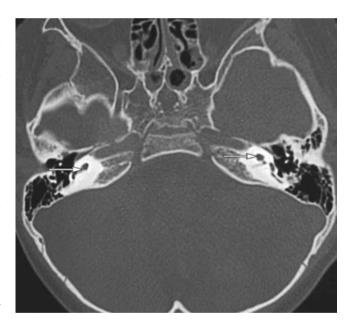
Mondini malformation of bilateral inner ear (arrow) CT scan
